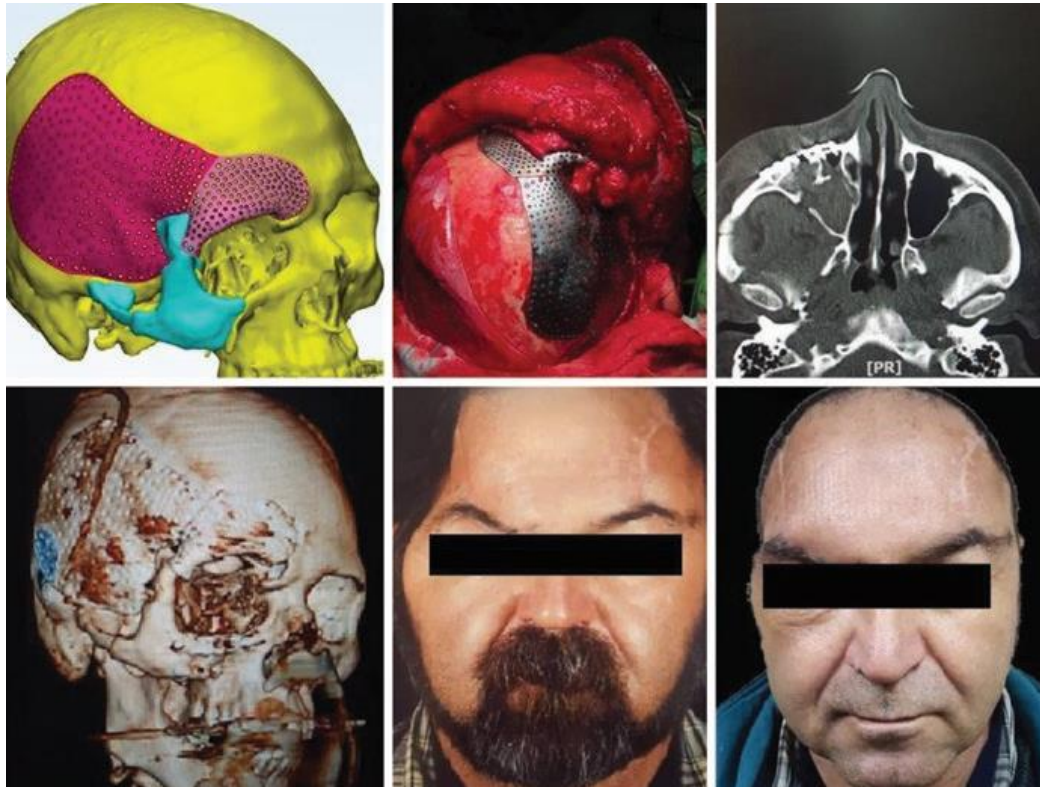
Shows the prosthesis to replace the contour of the calvaria, orbit, and zygoma. (a) Prosthesis design. (b) Placement and fixation of the PSI. (c) Postoperative CT scan in the axial cut shows the zygomatic part of the prosthesis. (d) Three-dimensional reconstruction of the postoperative CT scan. (e) Preoperative photography of the patient, the defect is evident on the right side of the face. (f) Postoperative photography of the patient (44).
